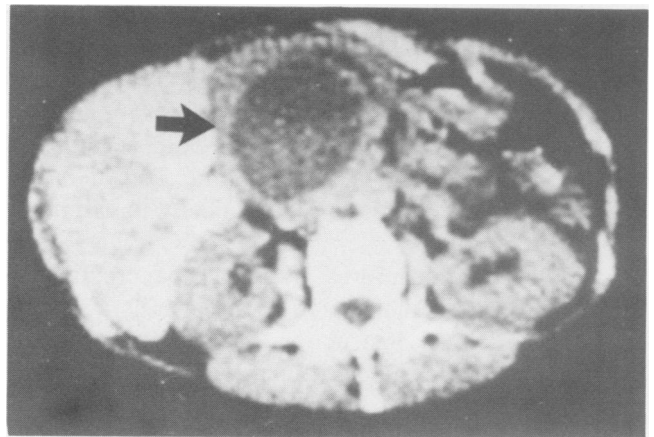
CT scan showing a large pseudocyst in the head of the pancreas (arrow) (Case 3).
